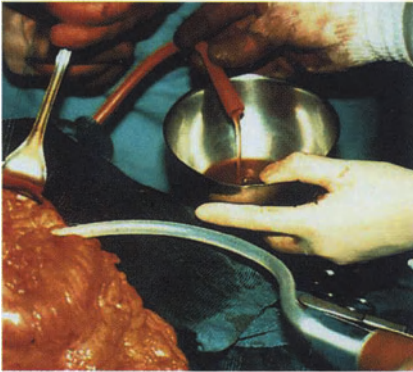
C,D. Ultrasound findings are confirmed by targeted surgical exploration (C) followed by drainage positioning (D) (Personal experience). Ch.2, p. 29.
